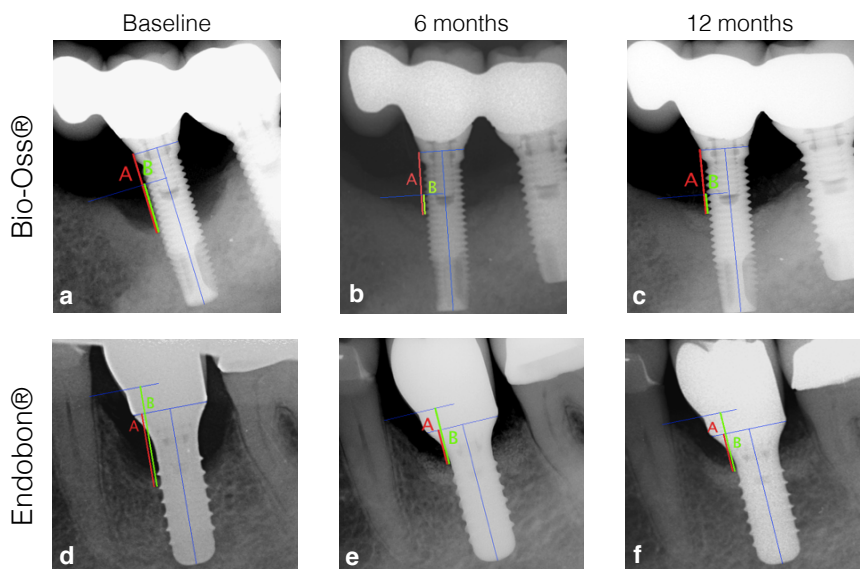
Radiographic assessment of: A) bone level (red line) and, B) intrabony defect depth (green line) at baseline, 6 and 12 months after treatment at an implant treated with BO (a-c) and EB (d-f).
